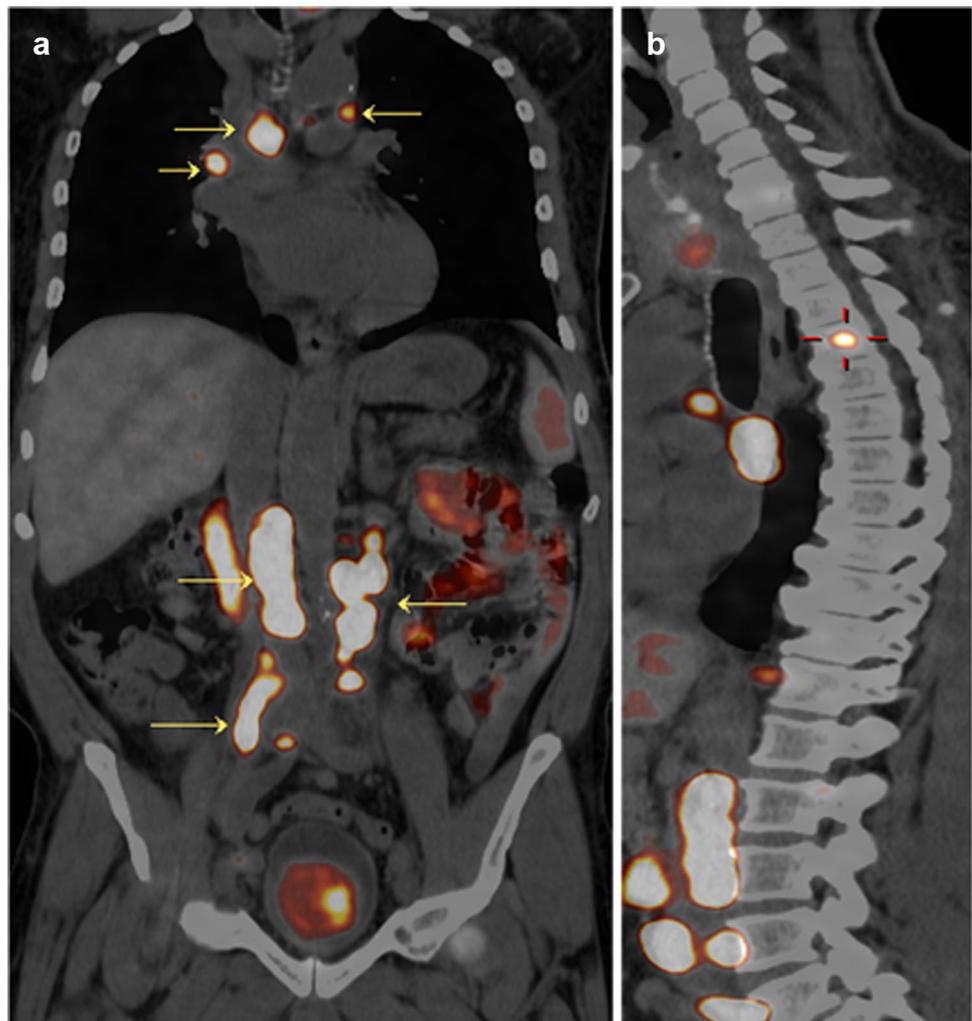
A 55-year-old man with newly diagnosed PC referred for initial staging (PSA level: 5.9 ng/mL; GS: 3+4). a Axial and b Sagittal ^{68}Ga -PSMA PET/CT images showing an average size prostate with a
